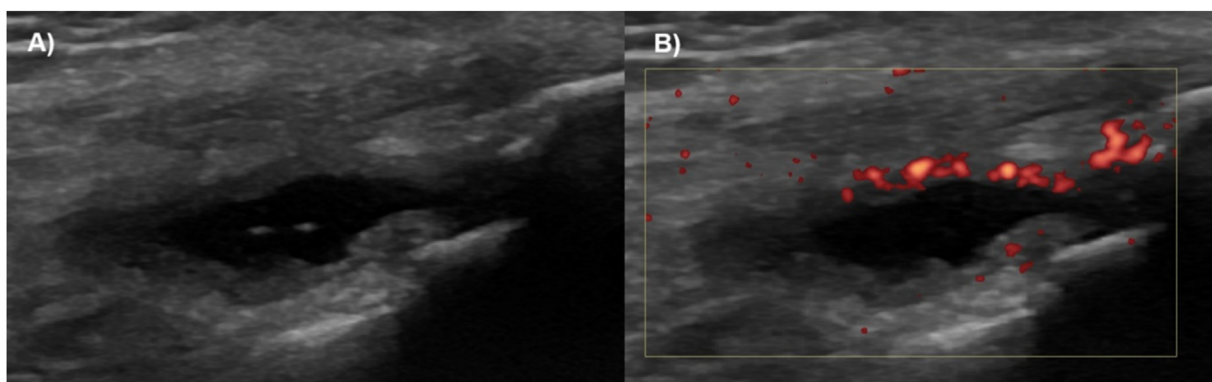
A) Greyscale suprapatellar US image of knee synovitis. B) Corresponding greyscale image with PD box overlaid- orange Doppler pixels within hypertrophic synovium indicate the presence of blood flow.
